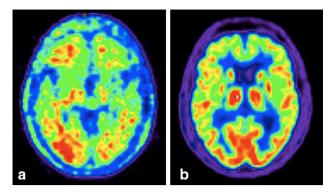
Example case of cognitively intact subject (74 years old, education: 5 years) with positive amyloid PET (a) and negative FDG PET (b). a amyloid PET shows A $\beta$  accumulation in frontal, temporal and occipital lobes, more pronounced in the right hemisphere. b FDG PET scans shows normal brain metabolic activity, particularly in temporo-parietal regions
